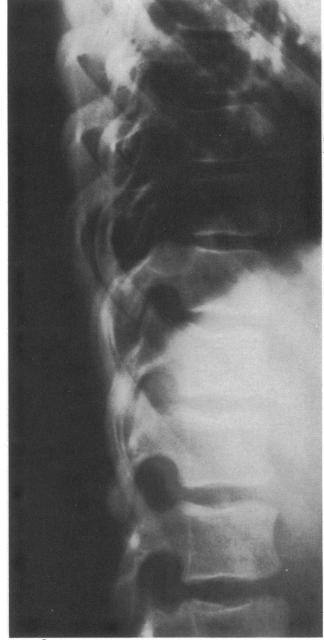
True lateral radiograph of the apex of an idiopathic thoracic scoliosis showing the apical lordosis.
